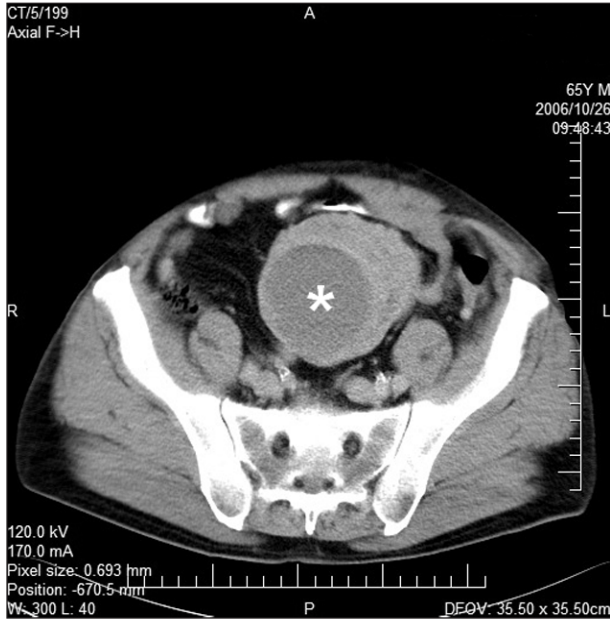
Computed tomography showing solid expansive non-homogenously enhancing mesenteric mass with peripheral cyst (asterisk).
